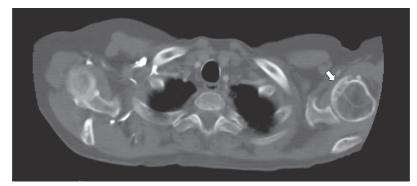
Contrast-enhanced computed tomography axial view of the shoulder joint showing osteophytes (arrows) in the humeral head.
